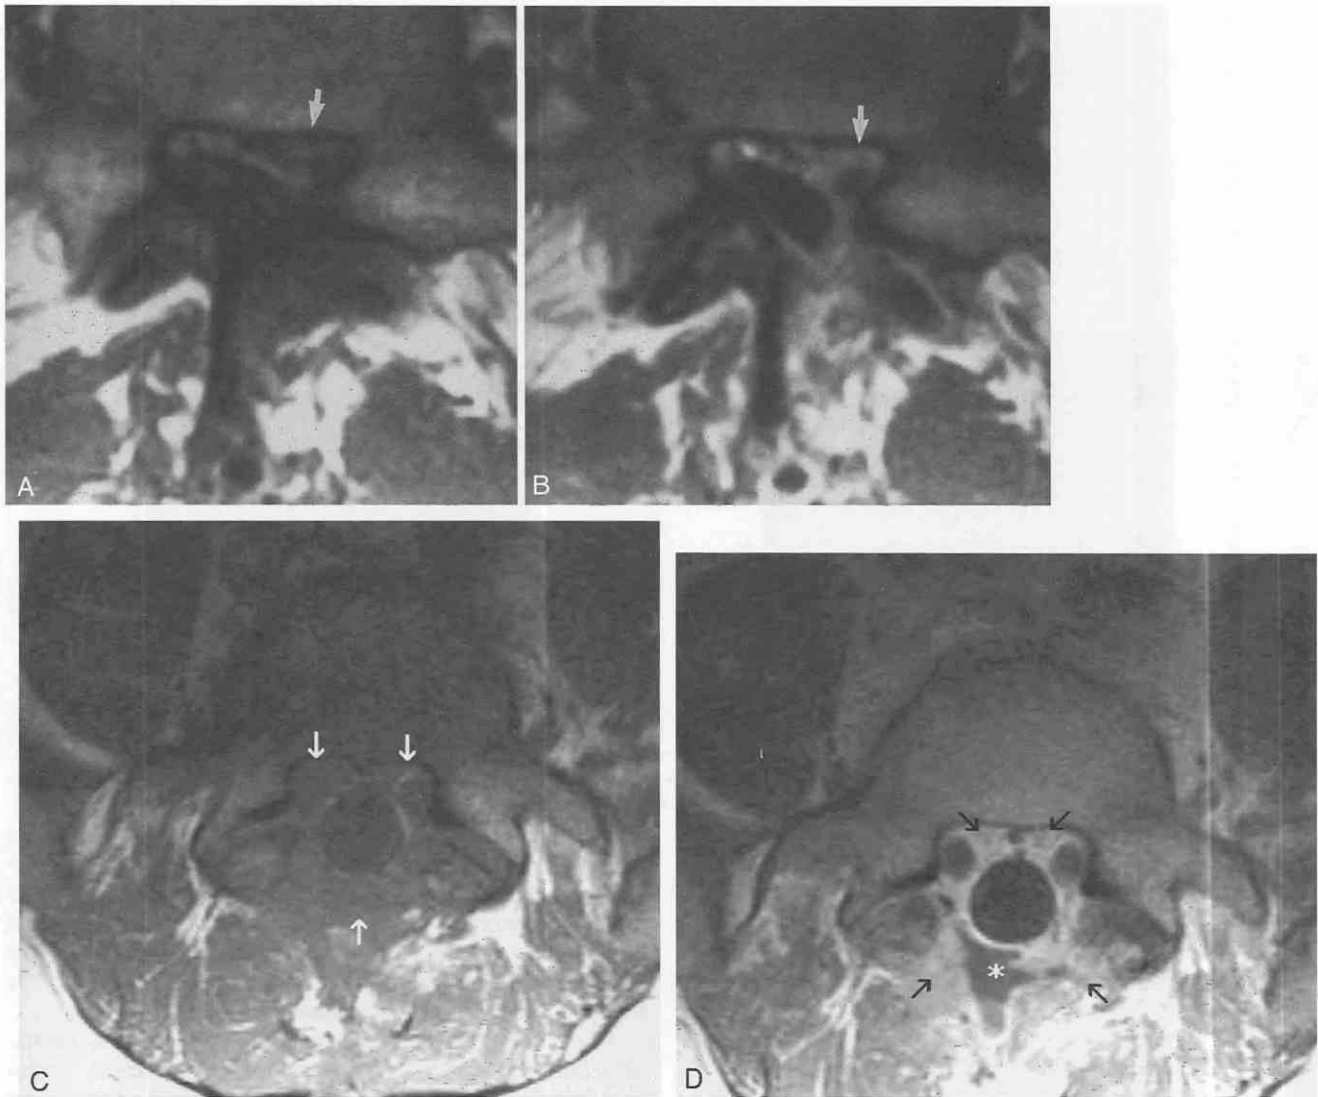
Same patient as in Figure 22-32. *A*, Axial unenhanced T1-weighted MR image shows an apparent recurrent disk herniation (arrow). *B*, After gadolinium administration, the scar tissue (arrow) enhances intensely, wraps the left L5 root, and compresses the thecal sac. No evidence of disk herniation is seen. Axial unenhanced (*C*) and enhanced (*D*) T1-weighted MR images demonstrate postoperative scar (arrows) in another patient. Note small, nonenhancing postoperative fluid collection (asterisk), which can be seen only after contrast administration. This is a common postoperative finding.
